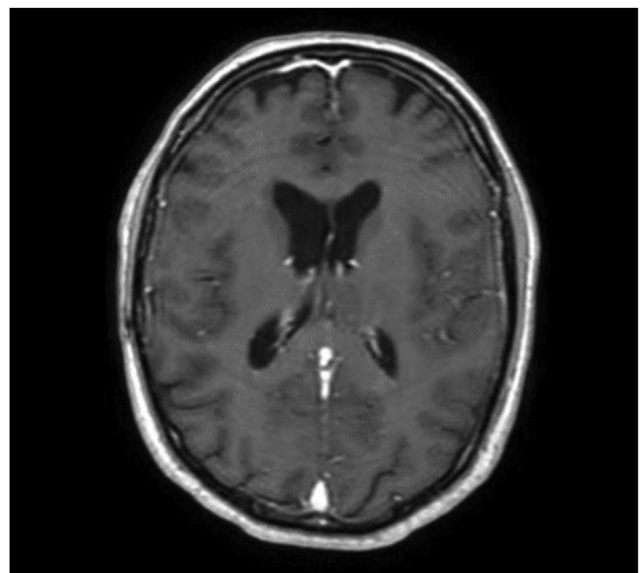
Brain MRI performed in February 2022 underlying brain complete response. MRI, magnetic resonance imaging.
